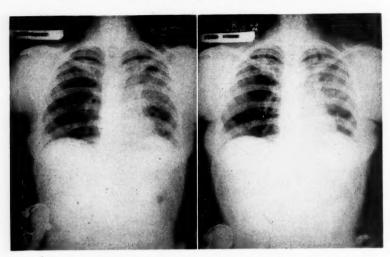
Case 3. Roentgenogram taken two months following the discontinuance of anti-nistamine therapy. Considerable spread of the mines. The spread seen in the left lung field lesions can be seen in the mid-lung field on the can be seen to have cleared. Amenorrhea left. This was accompanied by amenorrhea and ceased. Clinical course again reversed. a return of the symptoms of toxicity.
